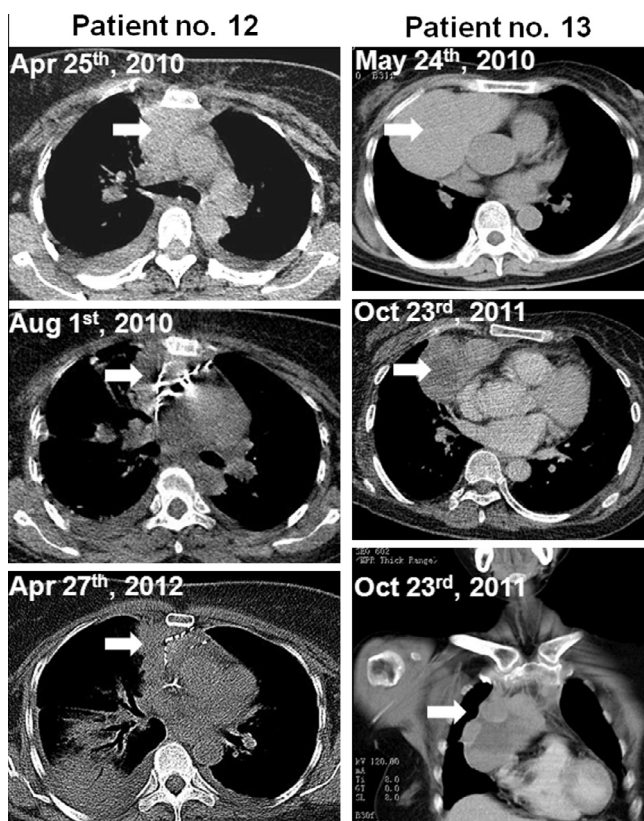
Complete, durable responses in two thymoma patients who underwent cryosurgery. The white arrows indicate the thymoma. The figures on the left are enhanced computed tomography (CT) images of patient no. 12 before and 24 months after cryosurgery and iodine-125 seed implantation. The figures on the right are enhanced CT images of patient no. 13 before and 17 months after cryosurgery.
